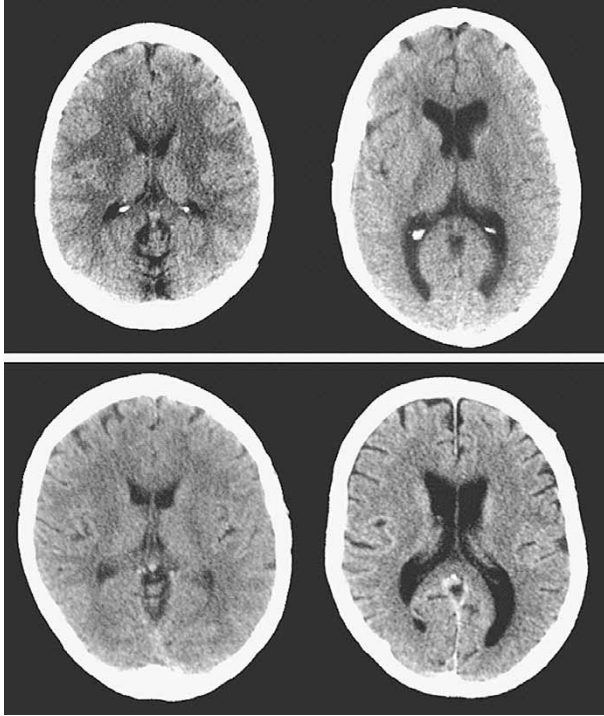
Brain CT scans in normal controls and patients with ARDS. The figure shows brain CT images in the axial plane through the mid body of the lateral ventricles in patients with ARDS and normal controls. The top row shows two 34-year-old women. On the left is the control subject and on the right is a patient with ARDS. The bottom row shows two 54-year-old men. The control subject is on the left and the patient with ARDS is on the right.
